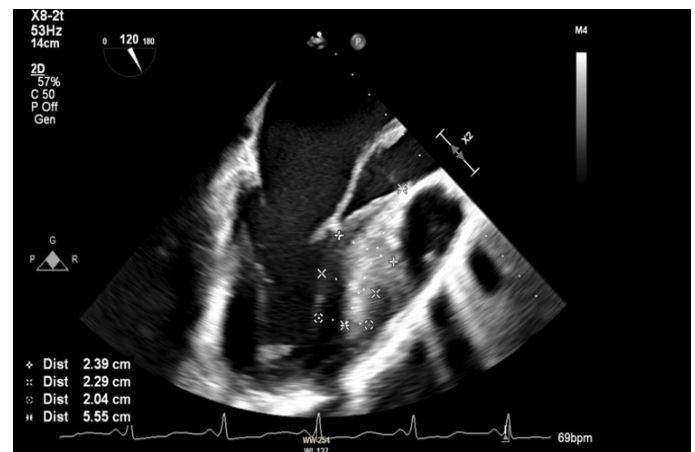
Transesophageal echocardiogram showing the characteristic features of hypertrophic cardiomyopathy with systolic anterior motion of the anterior mitral valve leaflet and basal septal hypertrophy (white arrow)
